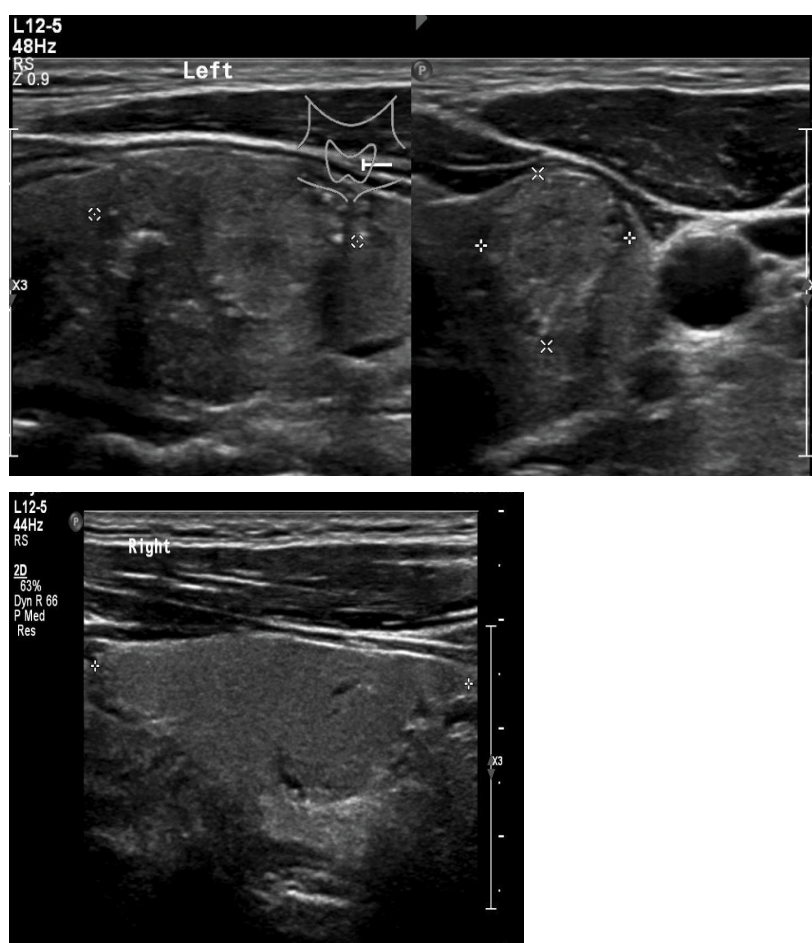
and Figure 2: Doppler US scan of thyroid gland showed, right lobe sharply defined hypoechoic thyroid nodule with cystic components and micro-calcifications in left lobe of thyroid.
